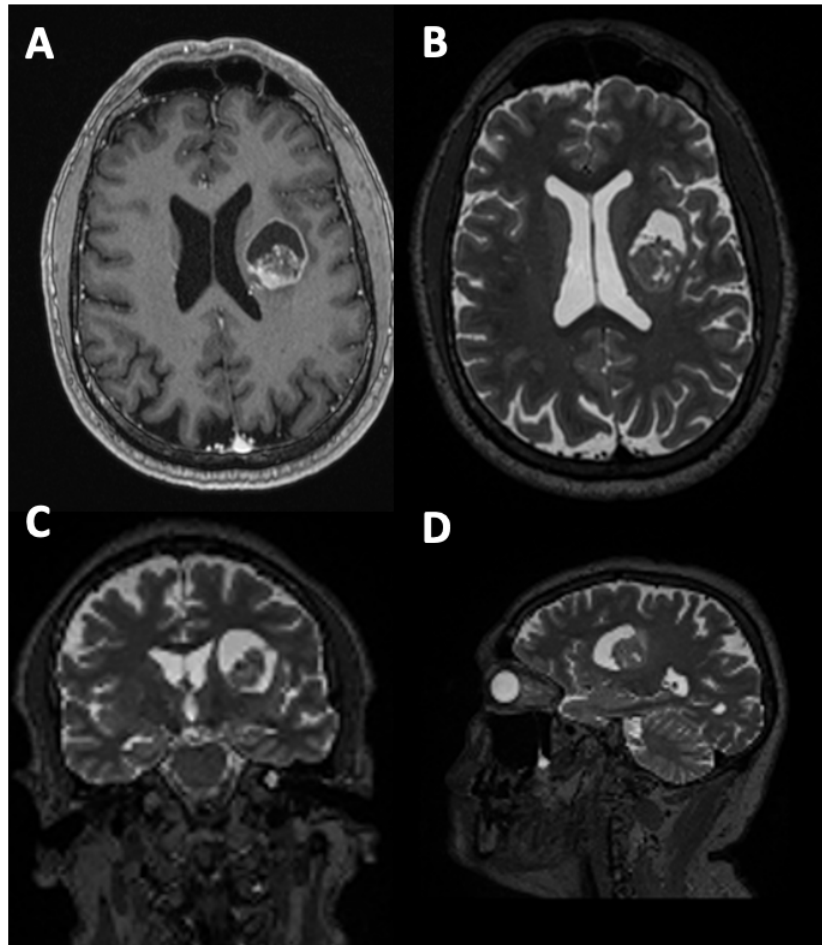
Diagnostic structural image – Axial T1-weighted with gadolinium (A), T2-weighted axial (B), coronal (C) and sagittal (D) images showing an intrinsic lesion with mixed cystic-solid characteristics within the anterior limb of corona radiata (central core).
